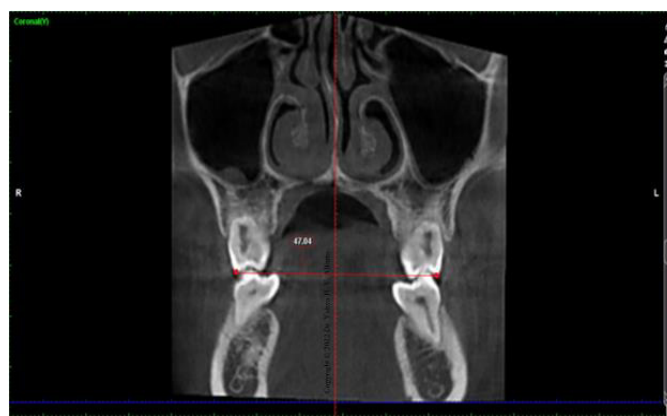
A CBCT image shows the distance of the inter first molar arch width measurement from the mesiobuccal cusp tip of one side to the mesiobuccal cusp tip of the contralateral side in the coronal view.
